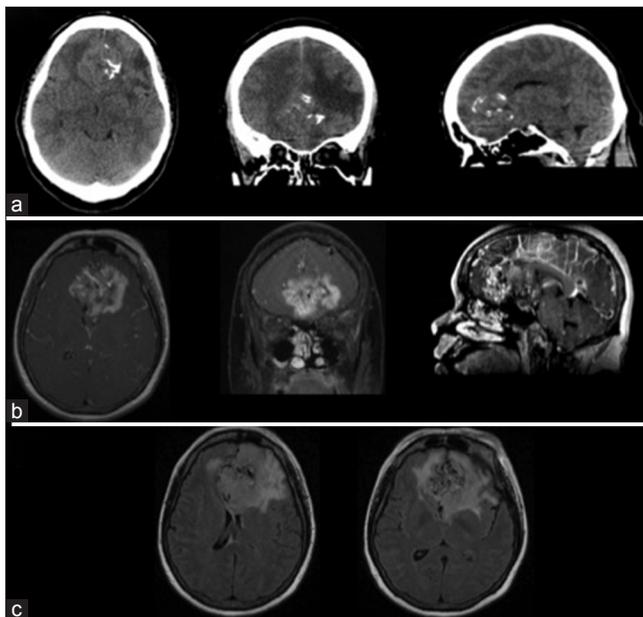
Pretreatment imaging: Computed tomography (a) T1 magnetic resonance postcontrast (b) and fluid attenuation inversion recovery (c) showing 6 cm × 5 cm × 5 cm bilateral frontal lobe mass with internal coarse calcifications, marked enhancement, and surrounding vasogenic edema with multiple flow voids and large draining veins. There is abnormal tissue interspersed between vascular elements and large areas of cystic changes and necrosis
